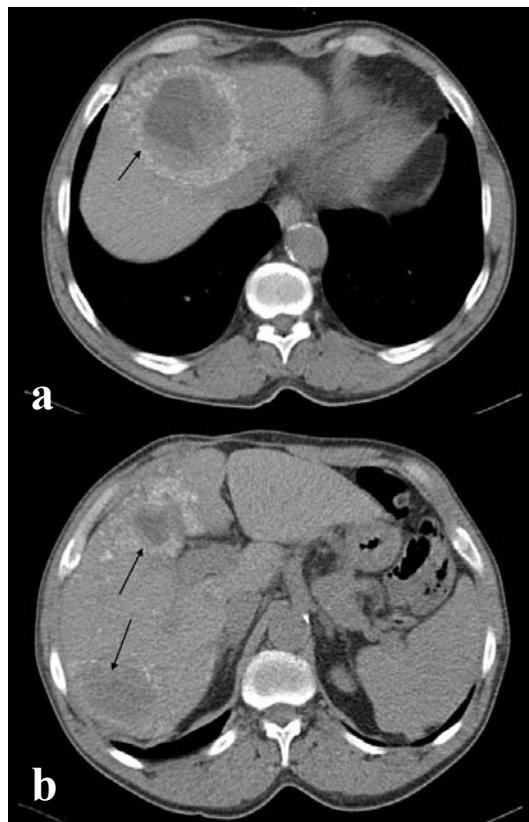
CT scan 6 months after cessation of PEG IFN treatment. Regression of primary Echinococcus focus in S8 with the creation of calcified margins (Fig. 4a, solid arrow). Regression of other focuses in S4 and S6 were observed (Fig. 4b, solid arrows).
